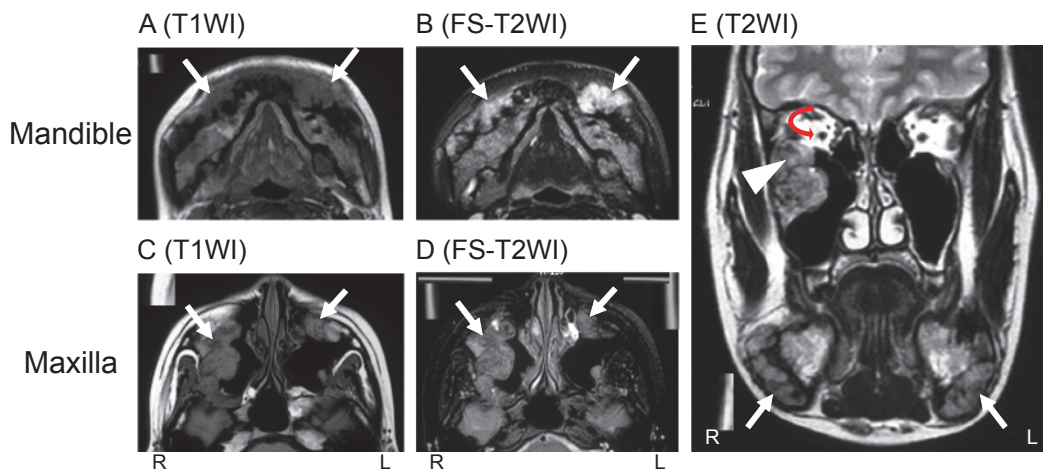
Magnetic resonance imaging detecting lesions (arrows) in both the mandible and maxilla with low-signal intensity on axial T1-weighted images (a, c: T1WI) and intermediate to high heterogeneous signal intensity on both axial fat-suppressed T2-weighted images (b, d:
